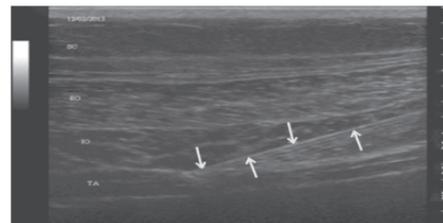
Transverse sonogram of lateral abdominal wall with in-plane image of needle. SC = Subcutaneous tissue, EO= External oblique muscle, IO = Internal oblique muscle, T = Transversus abdominis muscle, Arrows indicate needle shaft.
